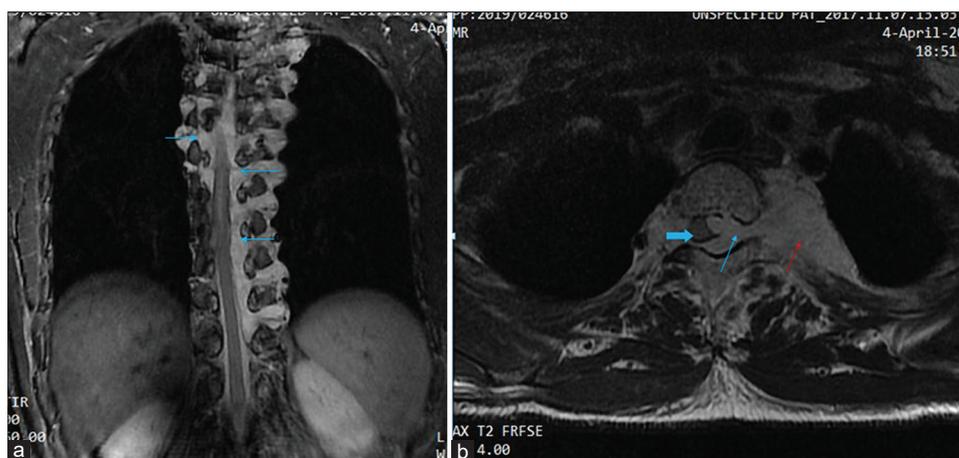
(a) Coronal short tau inversion recovery magnetic resonance image showing hyperintense lesion (blue arrows) in epidural space extending into adjacent neural foramina and paravertebral space (more prominent on left side). (b) Axial T2-weighted magnetic resonance image shows anterior and posterior epidural space lesion with extension into B/L neural foramina (thin blue arrow) and adjacent paravertebral space (red arrow). There is partial encasement and compression of the spinal cord with displacement towards right (thick blue arrow).
